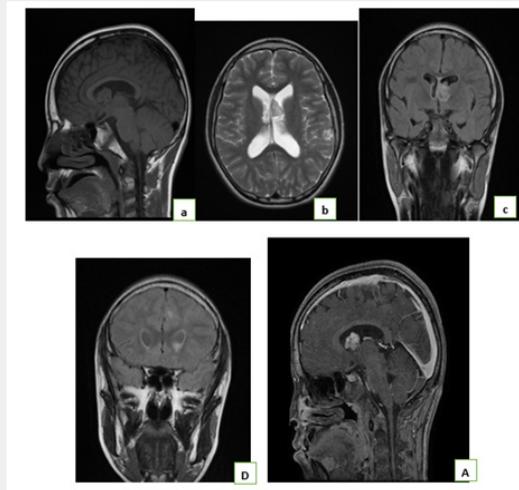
T1 sagittal cut cerebral MRI before(a)and after injection of gadolinium (e),axial T2(b)and FLAIR coronals (cc and d)showing a giant cell astrocytoma of the left lateral ventricle above Monro's hole, in hypo signal T1 (a)and heterogeneous signalT2(b) and-FLAIR (cc), enhanced after injection of gadolinium (ee),associated with signal abnormalities of the cerebral cortex visible only on the sequence FLAIR(d) in relation to cortical tubers.
